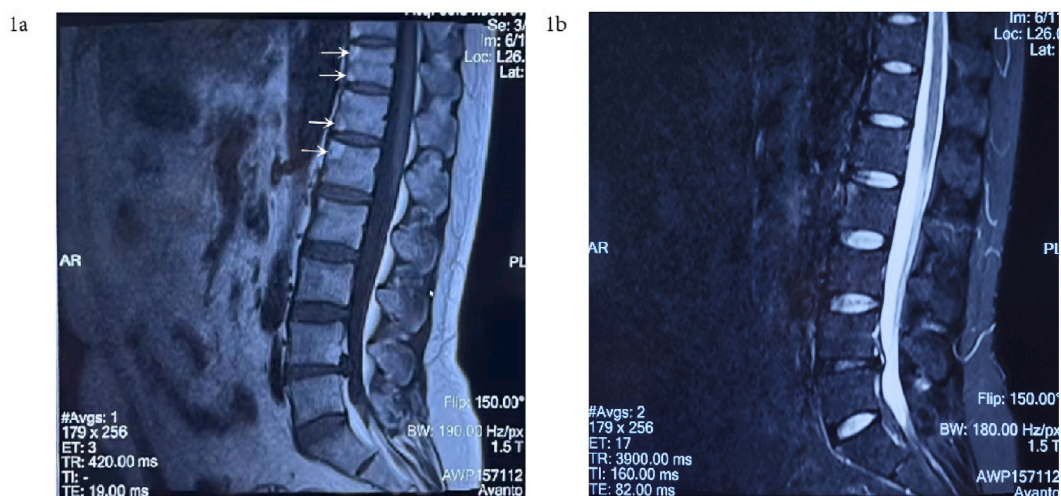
(1a) Lumbar MRI T1 sequence, fat deposition as shown in the arrow; (1b) STIR sequence images of the same lumbar spine.
